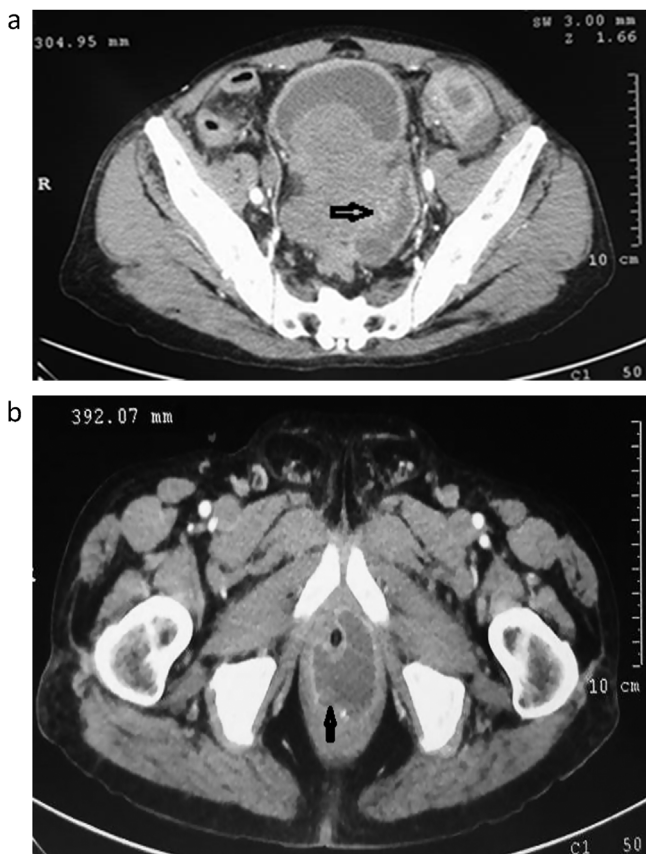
(a) Axial computed tomography image showing a huge prostate with abscess (arrow). (b) Axial computed tomography image showing a huge prostate with abscess (arrow).
